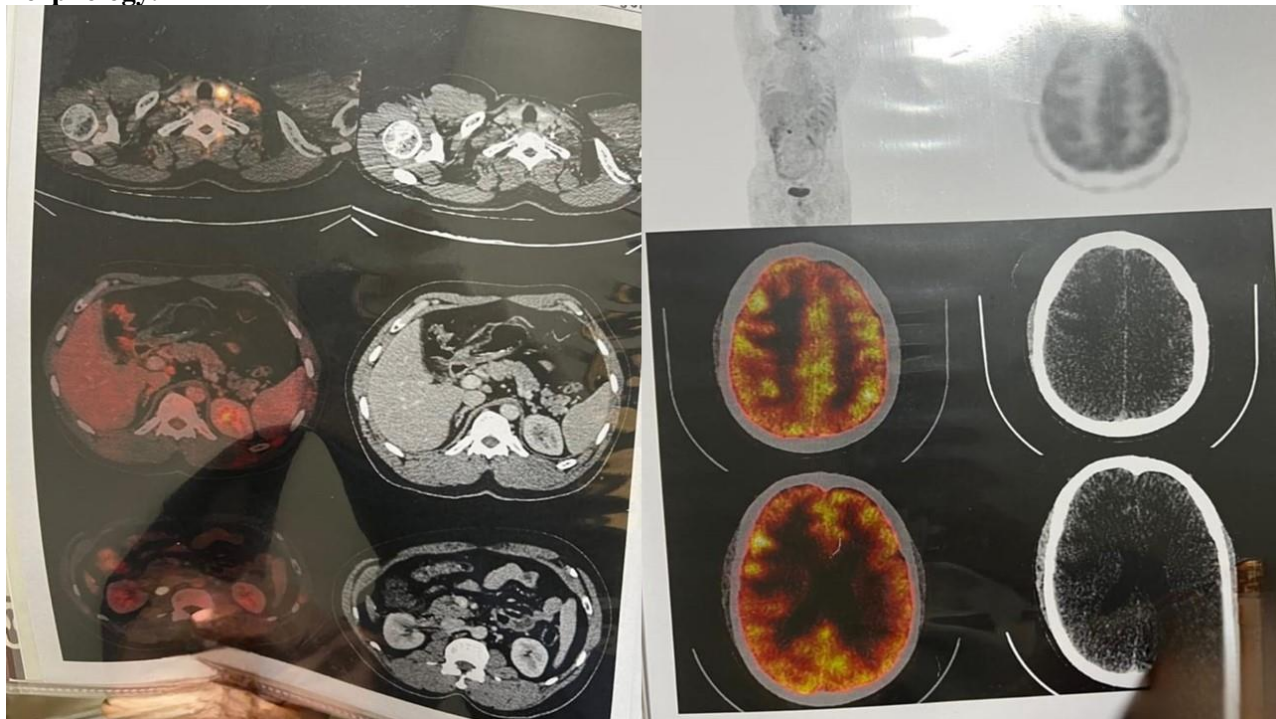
FDG-PET scan showing FDG-avid bilateral supraclavicular, a few abdominal and sub-centimetric retroperitoneal lymph nodes, as well as a thyroid nodule.
